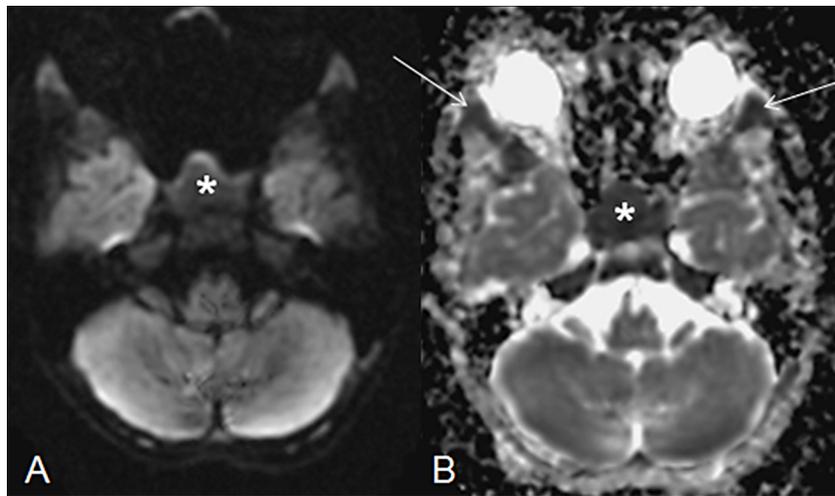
DWI with trace image (A) and corresponding ADC map (B) also demonstrate diffusion restriction within the sphenoidal mass (asterisk). Note the mass has similar signal intensity with the orbital wall (arrows).
